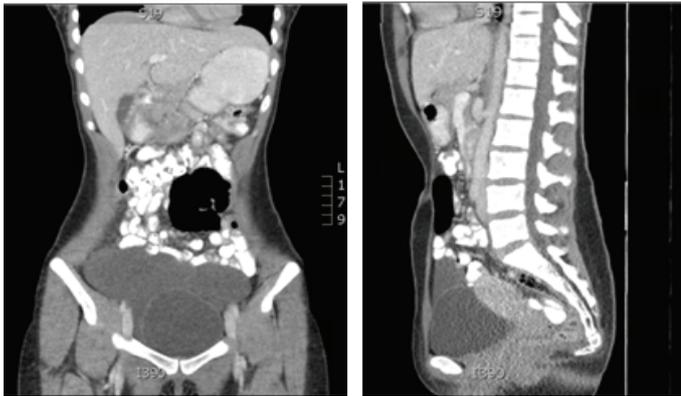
Computed tomography scan (sagittal and coronal views) showing the large fluid-filled multi-septated pelvic cyst.
